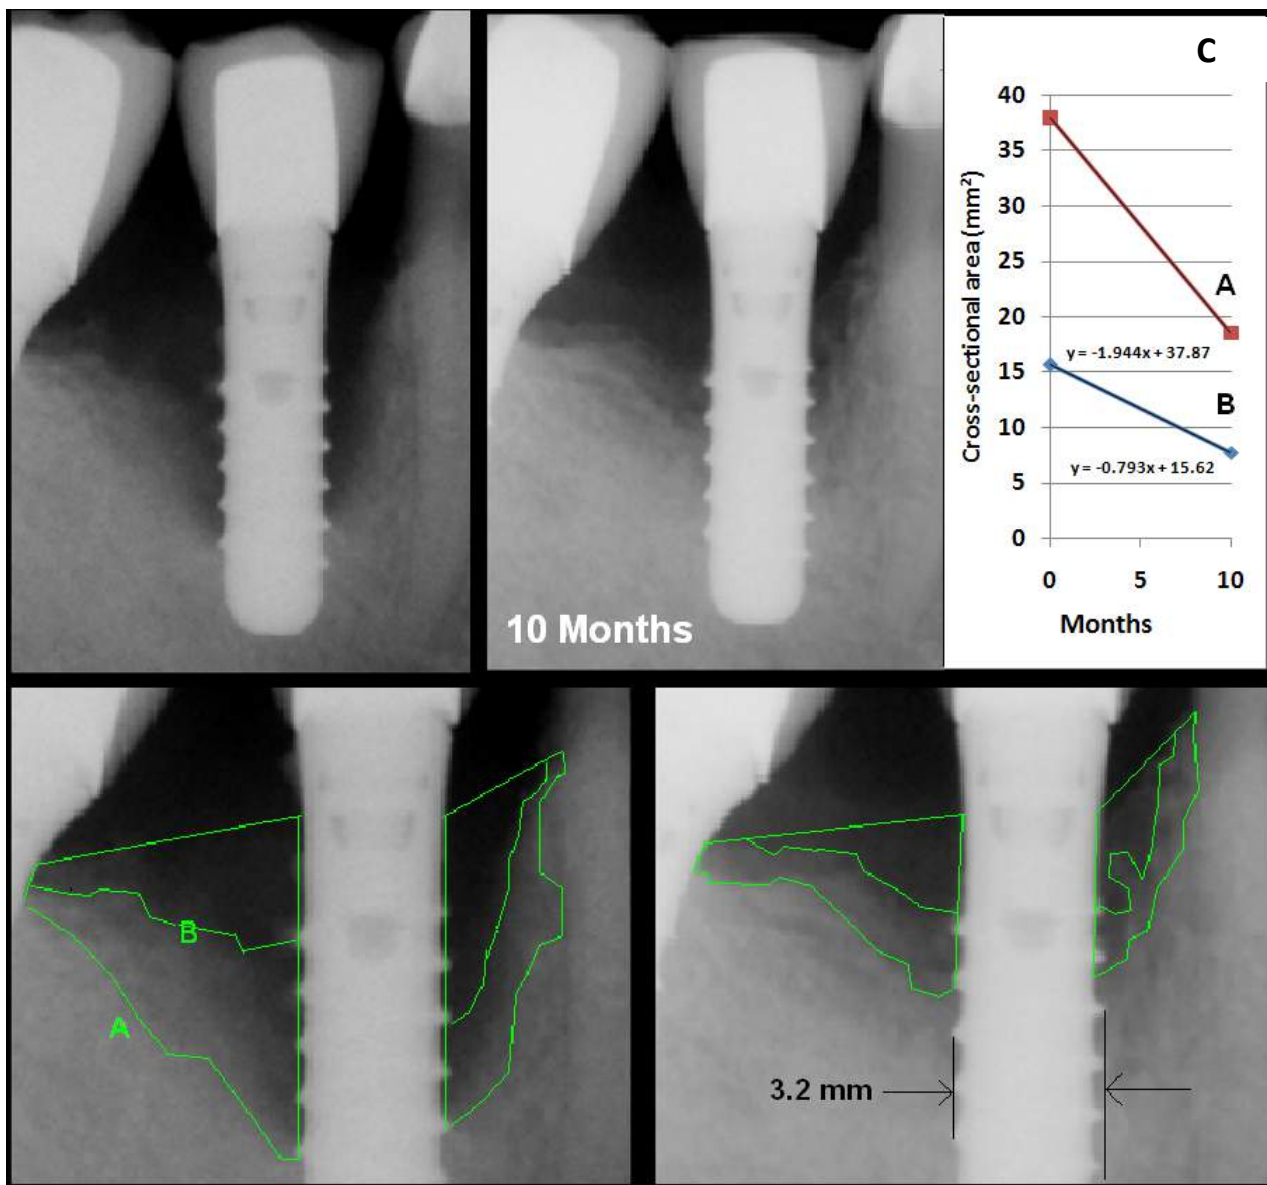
Case of peri-implantitis 3 years post-implant in a 51 year old male provided by Dr. Lamas. Two different contours are identified in these images. The “x-ray shadow” within the alveolar bone is assumed to represent bone loss resulting in decreased radiodensity (contour A). Completely black areas (there may be a slight of soft tissue background) are assumed to represent areas where bone is absent (contour B). C. The change in cross-sectional area was at a rate of 1.94 mm<sup>2</sup>/month for the entire lesion. The decrease in the black area (growth of new bone) was at a rate of 0.792 mm<sup>2</sup>/month [approx 1.6 mm<sup>3</sup>/mo].
